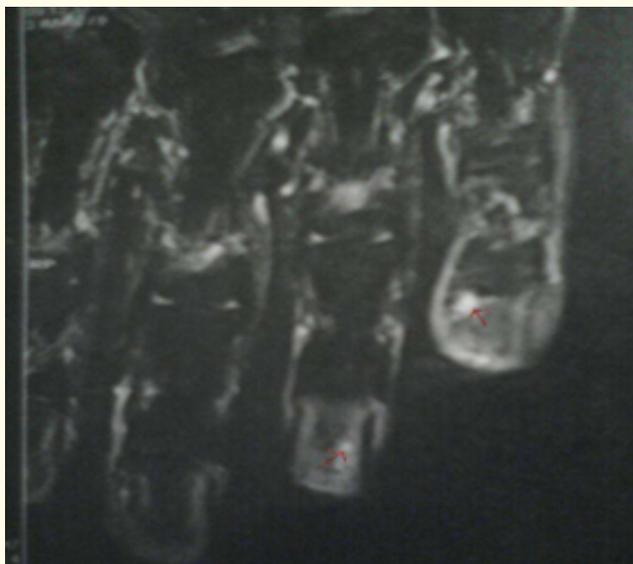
MRI findings of the distal phalanx in little finger and in ring finger of the left hand. A mass is detected at the subungual area and adjacent to the distal phalangeal bone of the little and the ring finger.
